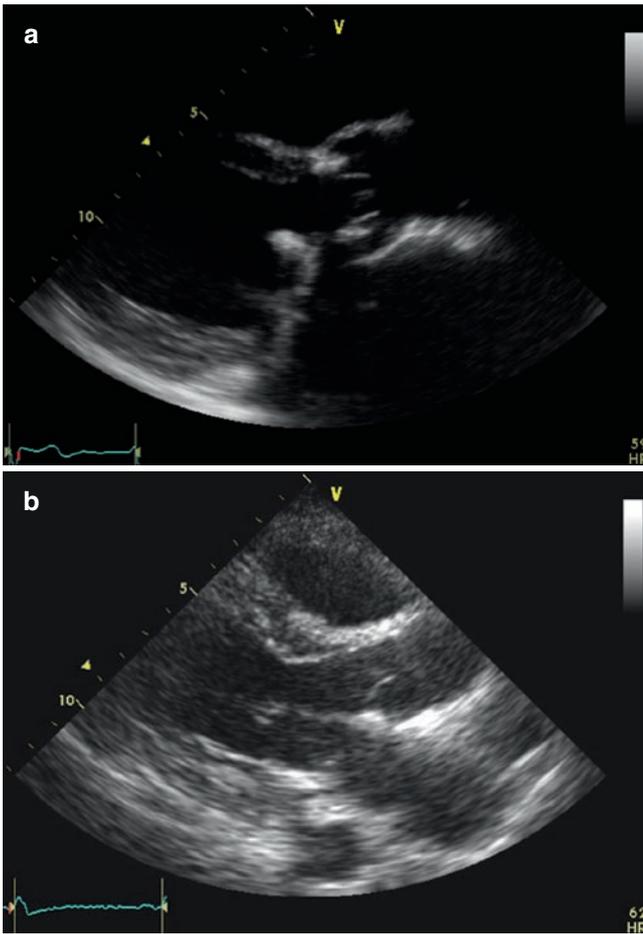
Two dimensional echocardiographic characteristics of bioprostheses: stented bioprosthesis (Mosaic 23 mm) in aortic position visualized from parasternal approach (a) and stentless bioprosthesis (Freedom 21-mm) in aortic position visualized from parasternal approach (b)
